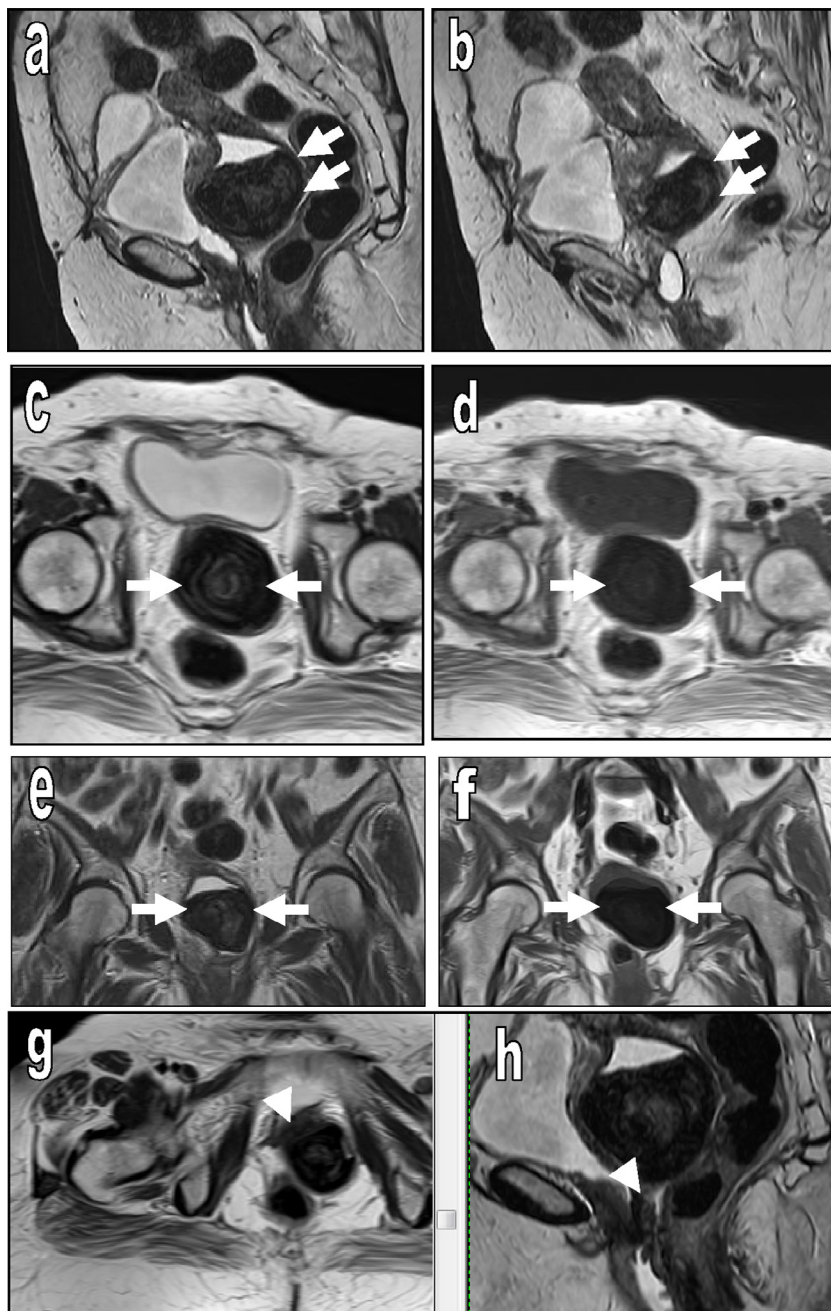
MRI examination: (a and b) sagittal T2 WI, (c and d) axial T2 and T1 WI, (e and f) coronal T2 and T1 WI. The vaginal stone appears as large structure of dark T1 and T2 signal lodged at the upper part of vagina below the cervix (arrows). Note the presence of fluid of low T1 and high T2 signal within the vagina above and below the stone. The irregular shape of the urinary bladder is assumed to be consequence of prior repair trials. (g and h) axial T2 WI and sagittal T2 WI showing the site of the vesico-vaginal fistula (arrow heads).
